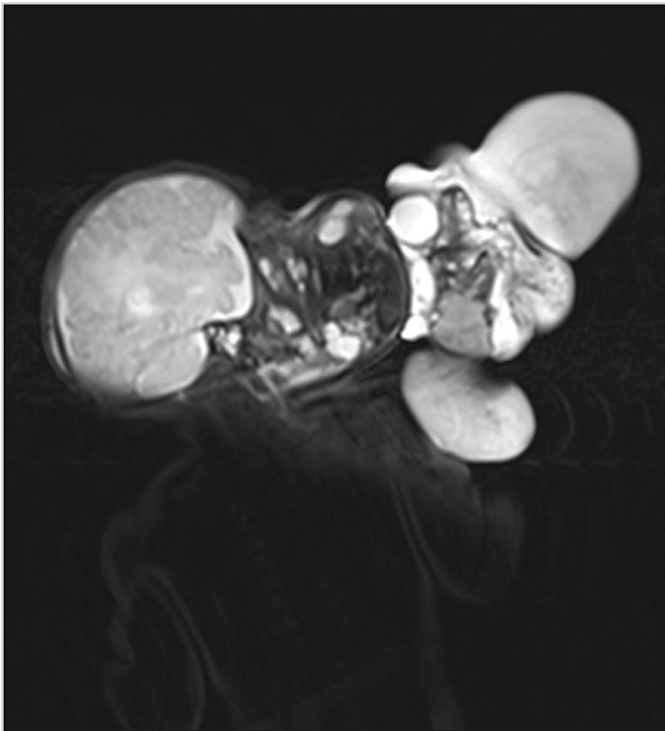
The preoperative T2 weighted MRI coronal section of the mass. Heterogeneous mass with cystic and solid components that associated with tonsillar and buccal region, protruding from oral cavity
